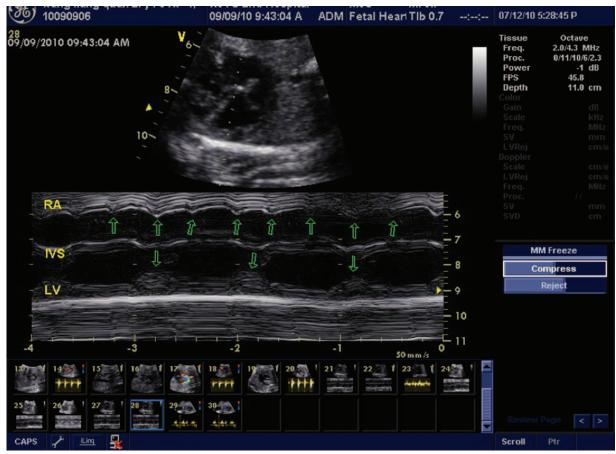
Fetal echocardiogram showed a complete atrioventricular block.
